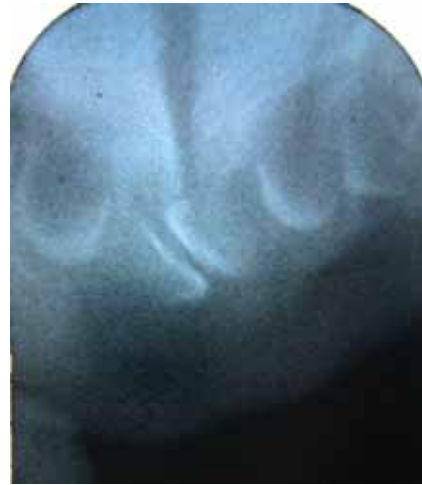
Intra-oral radiograph of lesion showing undischarged tooth buds.
